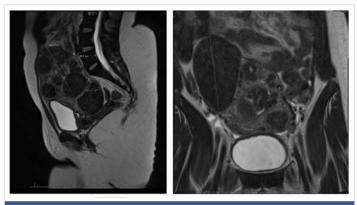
MRI imaging of pre-operative uterus with multiple large leiomyomas.
